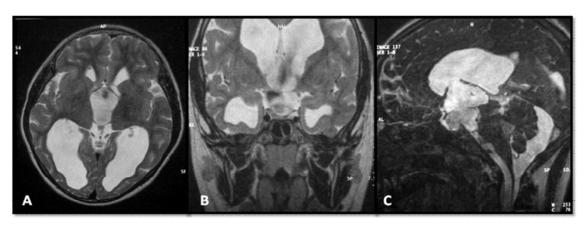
A & B, postoperative axial T2-WI and coronal T2-WI showing a reduction of the size of the suprasellar cyst. C, sagittal CISS-3D MRI displaying CSF flow void sign of the ventriculocisternostomy
